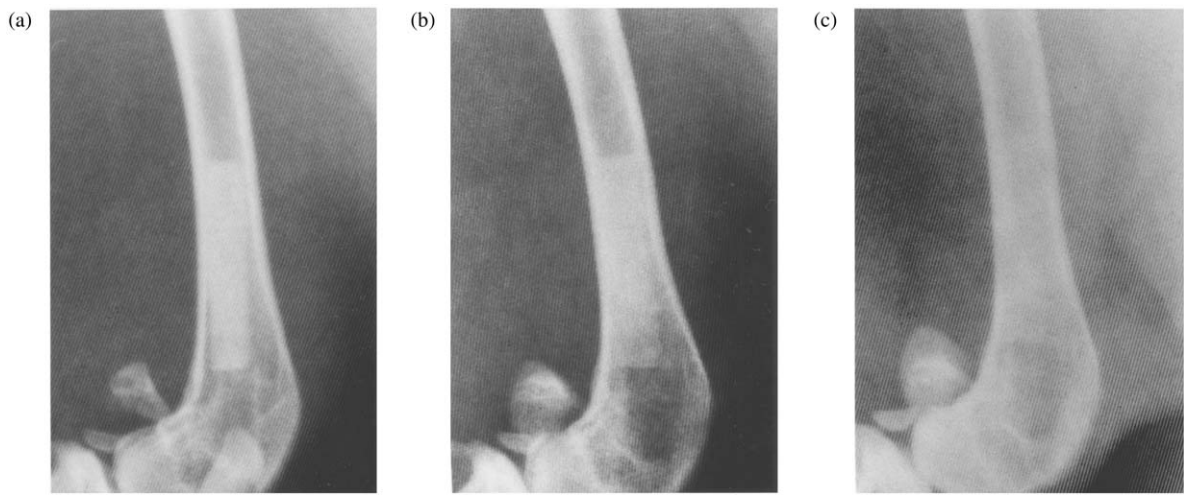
Radiographic changes in AW (a–c). (a) Day of operation; (b) at six months, and (c) 12 months after operation. AW became unclear and disappeared gradually.
